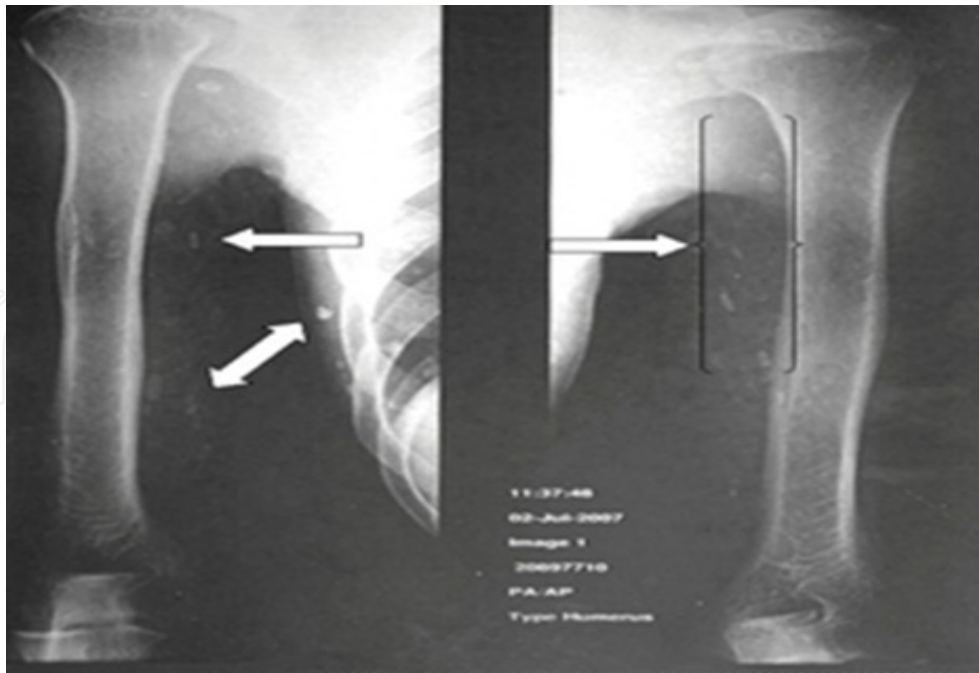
Plain X-ray of the chest and upper limbs show multiple subcutaneous and intramuscular “cigar-shape” calcifications.
